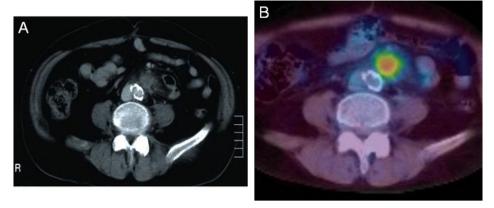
Panel A: A CT scan of the abdomen revealed a 2.0 cm para-aortic lymph nodes swelling. Panel B: A positron emission tomography (PET)-CT scan confirmed this para-aortic lymph nodes swelling as well as showed that thickened wall of the small intestine. Fluorodeoxyglucose (FDG) accumulation was observed by PET-CT.
